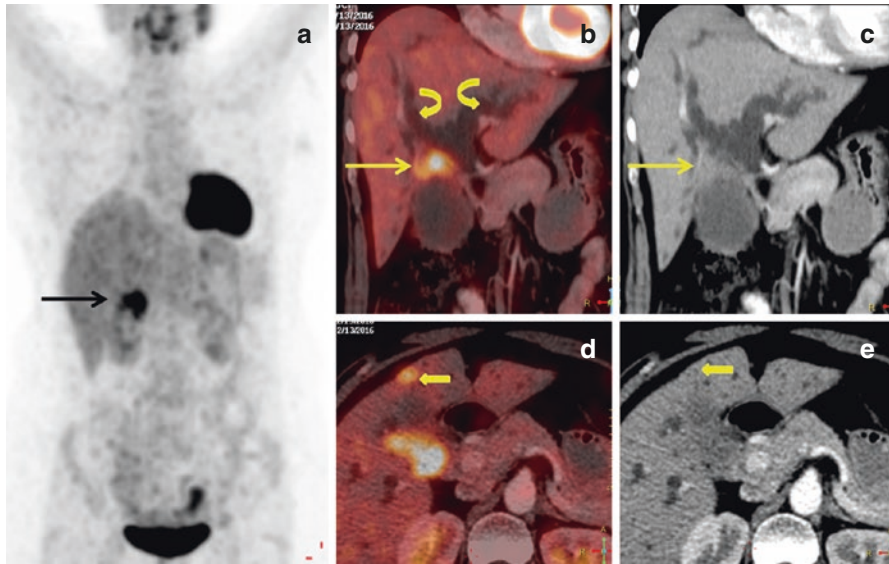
^{18}F -FDG PET/CT study of a 52-year-old lady with GB cancer. The study shows a hypermetabolic soft tissue mass (maxSUV 9.4) in the neck of the gall bladder (*arrow* in a–c) with bilateral intrahepatic biliary radical dilatation (*curved arrow* in b). The block arrow in d, e shows a focal hypermetabolic area in segment IVB, which was along the biliary radicals suggesting focal cholangitis (*block arrow*)
